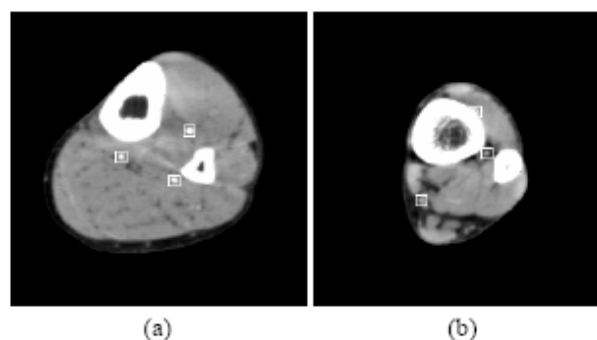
Experimental result of CTA image. (a) shows slice number 0, (b) shows slice number 123 (b). Each rectangle areas on the image show the extracted artery regions.
